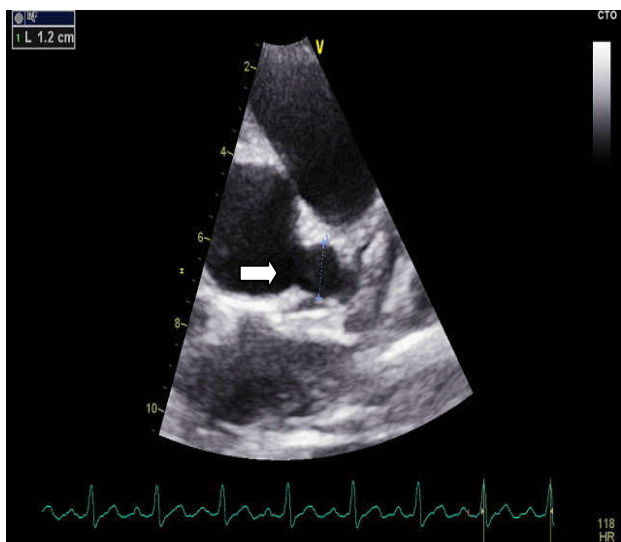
Echocardiography showing aneurism of the left anterior descending coronary artery with a diameter of 12 mm
